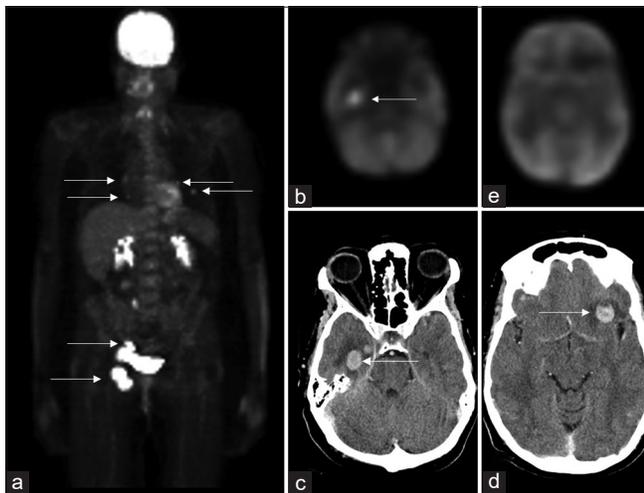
A 56-year-old female with primary melanoma site of vulva. (a) Skull vertex to the upper thigh maximum intensity projection image of ¹⁸F-fluorodeoxyglucose positron emission tomography/computed tomography (PET/CT) demonstrates right inguinal and pelvic lymph node involvement as well as bilateral pulmonary metastasis (white arrows). (b) Axial attenuation corrected PET and (c) axial contrast-enhanced CT show metastatic disease in the right temporal region (white arrows). (d) Axial contrast-enhanced head CT demonstrates metastatic disease in left frontal region (white arrows). (e) Corresponding attenuation corrected PET reveals no definite abnormality.
